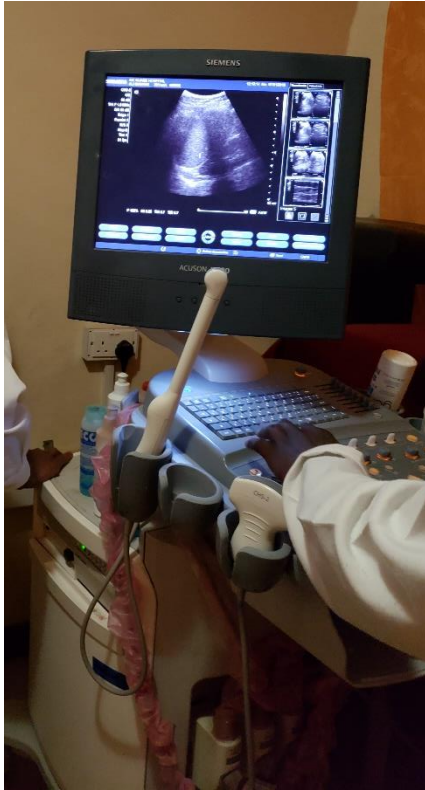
Siemens Acuson x300 Ultrasound Machine
